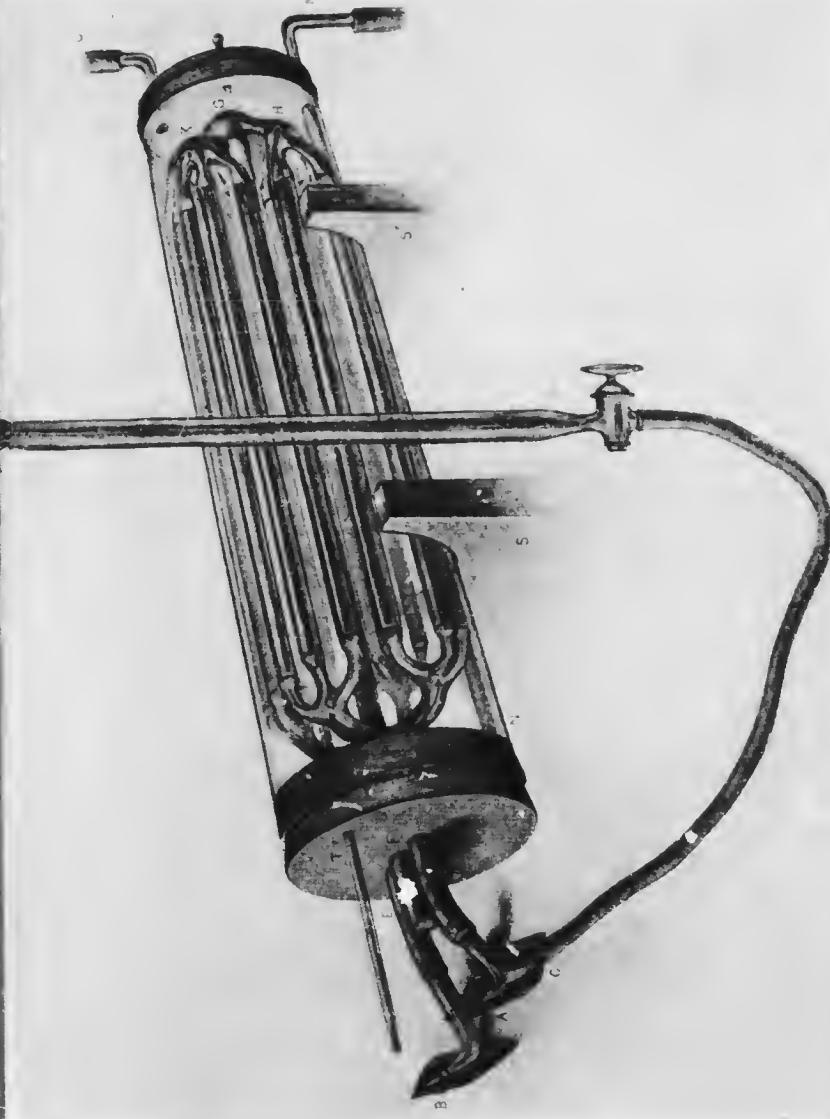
PERSPECTIVE VIEW OF VIVIPAROUS APPARATUS; EARLER FORAN WITH SIXTEEN TUBES
